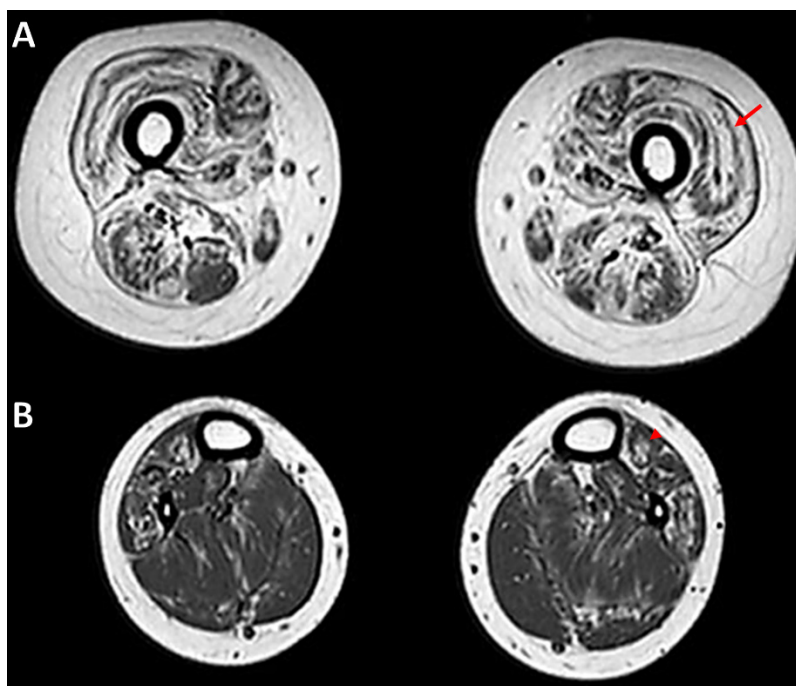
Muscle MRI of patient II-32. Axial chemical shift-encoded fat images of the (A) thighs and (B) calves showing a core of preserved muscle within the *m. vastus lateralis* (arrow), *m. vastus intermedius*, and *m. vastus medialis* and a focal area of degeneration in the *m. tibialis anterior* (arrowhead).
